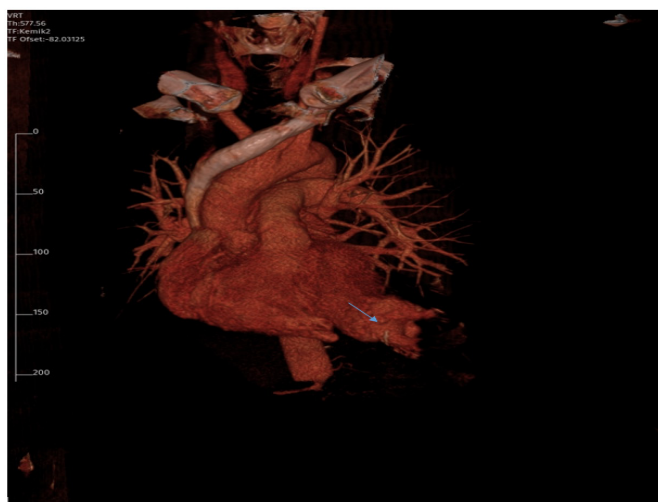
Three-dimensional view of left ventricular pseudoaneurysm on three-dimensional thoracic computed tomography
